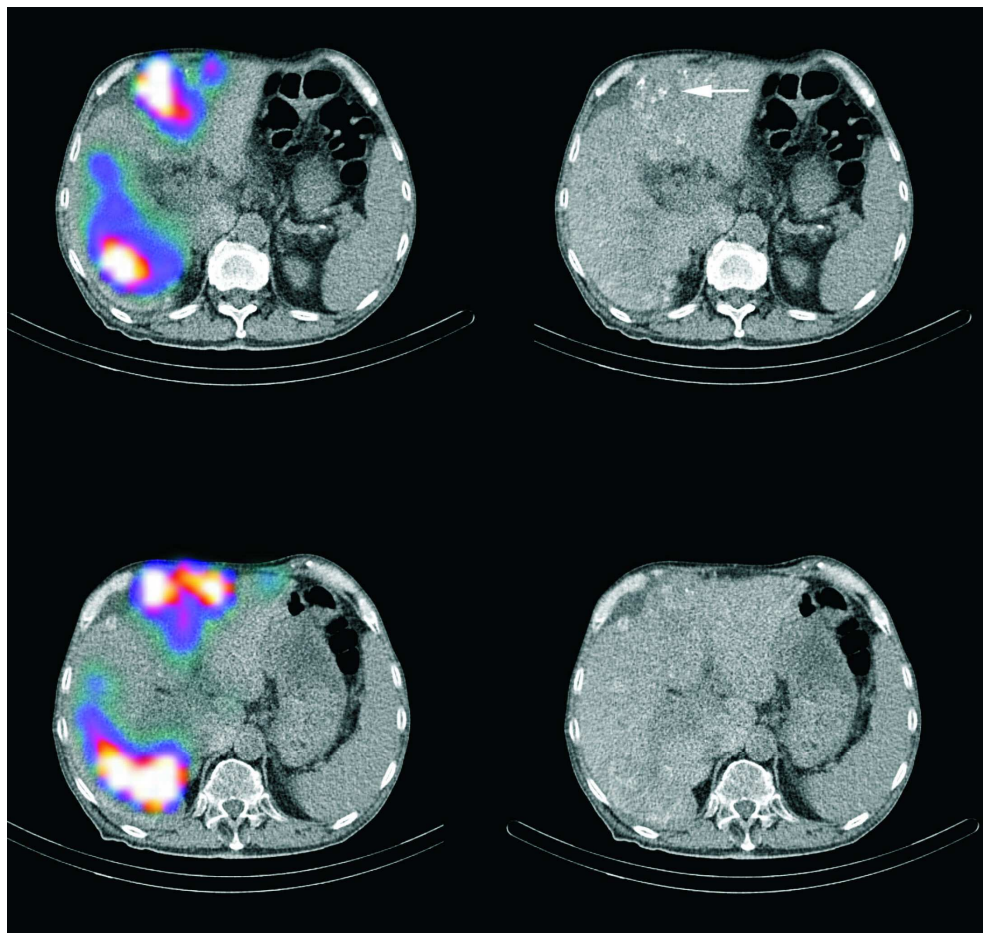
SPECT/CT of the liver could be used for a better quantification of the radioactive distribution as well as dosimetry simultaneously. Note the distribution of ¹³¹I-Lipiodol in the HCCs showed with arrow.
